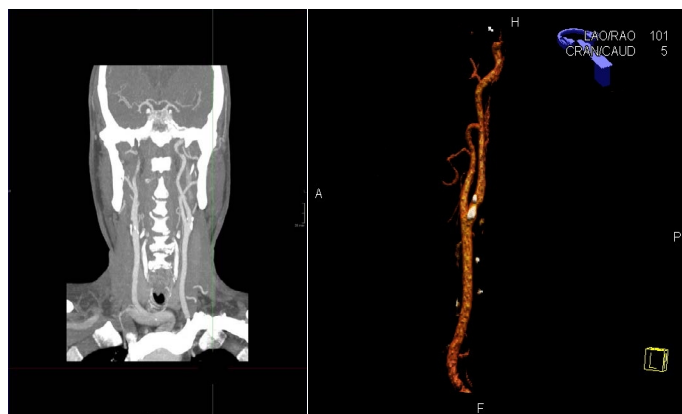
Angio-CT image of atheromatous plaque in the right internal carotid that causes a 70% stenosis.
